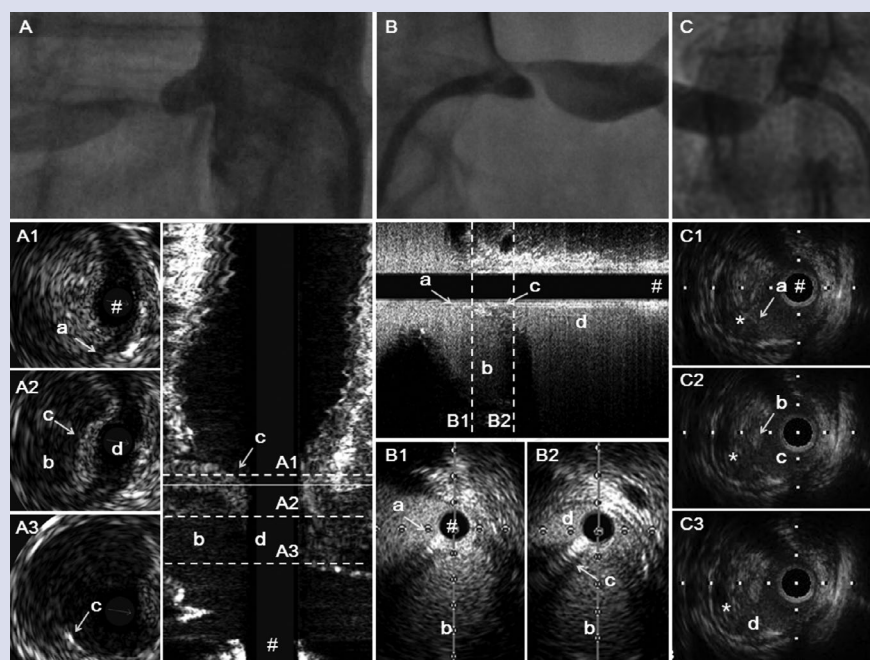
Angiograms of renal arteries and corresponding intravascular ultrasound images
